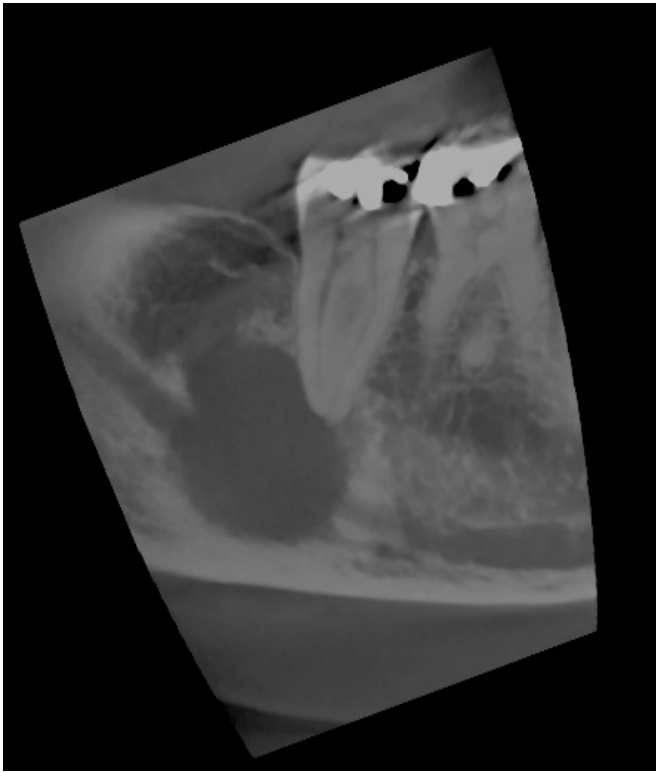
Pre-operative cone beam CT scan revealing enhanced visualization of the lesion in the longitudinal plane.
